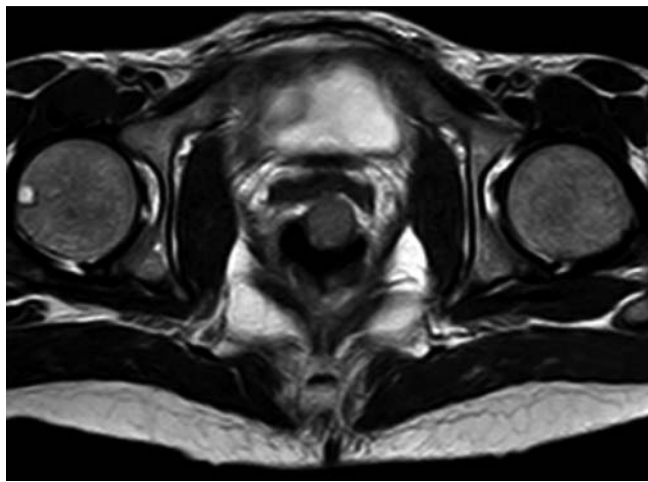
Magnetic resonance imaging (MRI) scan showing a rectal gastrointestinal stromal tumor (GIST).
